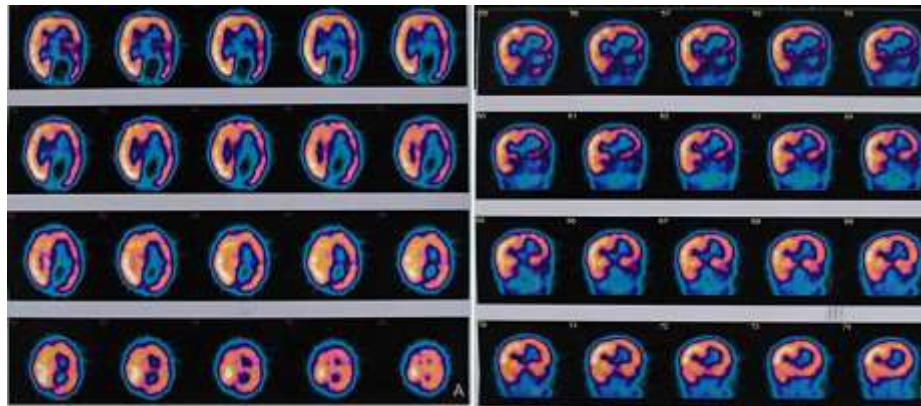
Brain SPECT showed images with decreased perfusion in the left side; the asymmetry was most pronounced in the occipital lobe: A axial and B coronal views
